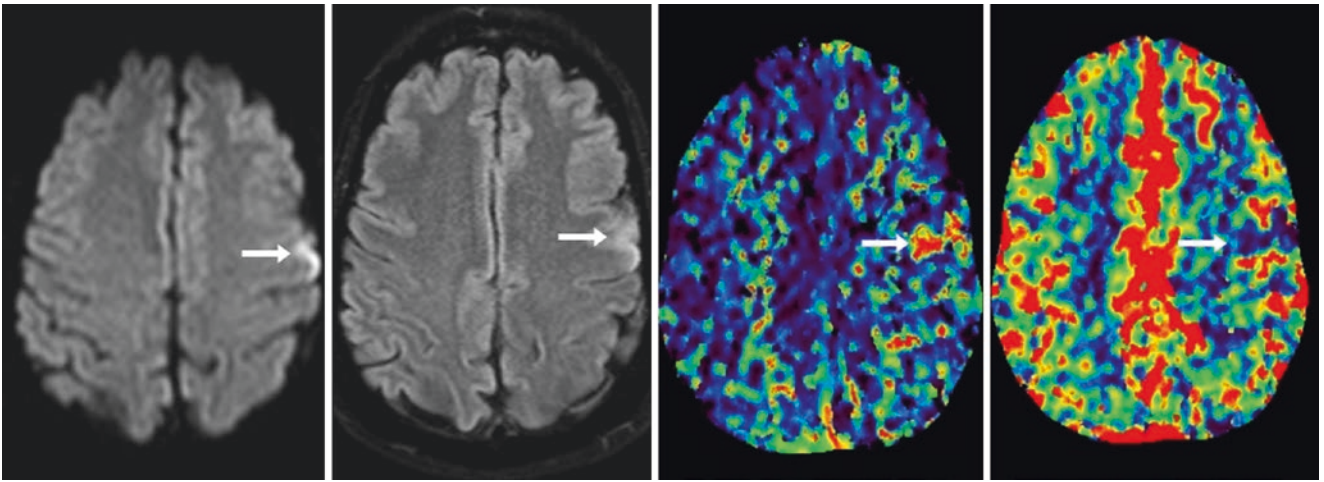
Comparison case of focal cortical infarct. In a 54-year-old with acute aphasia, a 1.5 T MRI DWI (*left*) showed focal bright cortical signal (*arrows*) that was not visualized on an ADC map (not shown) but was visible on FLAIR (*left middle*), and so was interpreted as positive. A CT perfusion exam performed earlier the same day
